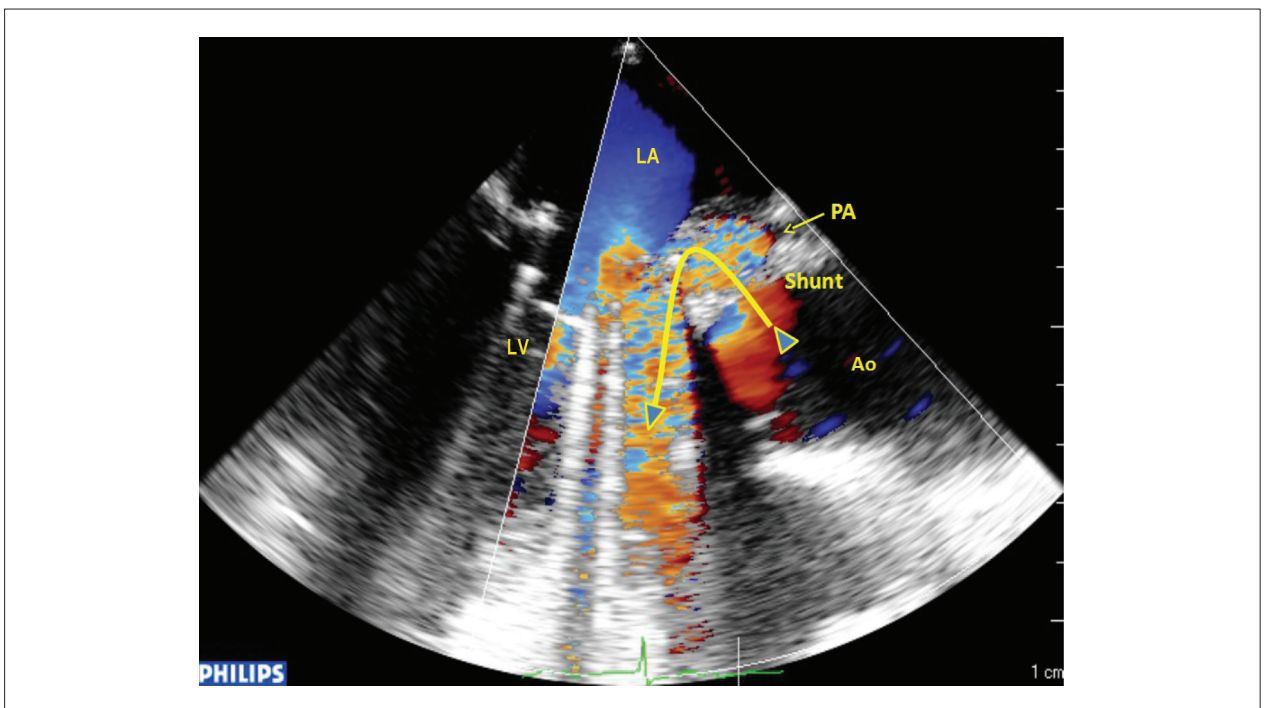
Transesophageal echocardiogram shows shunt flow, originating from the aorta (Ao), passing through the pseudoaneurysm and flowing into the left ventricle (LV); LA: left atrium.
